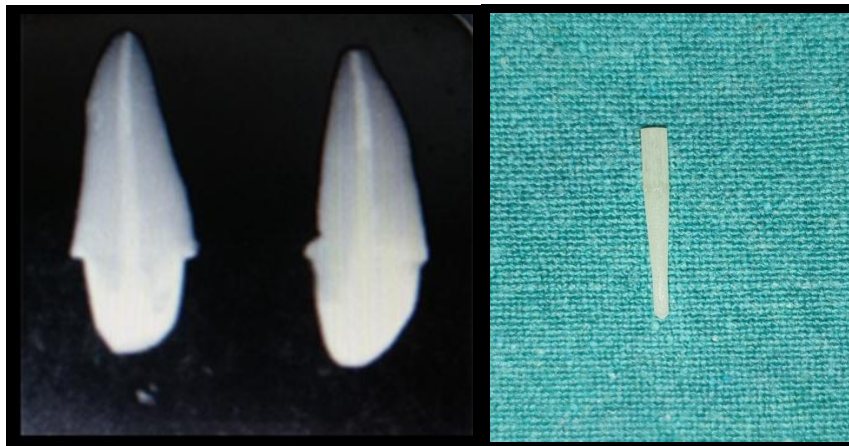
Radiograph of D.T Light treated samples and D.T Light post.
